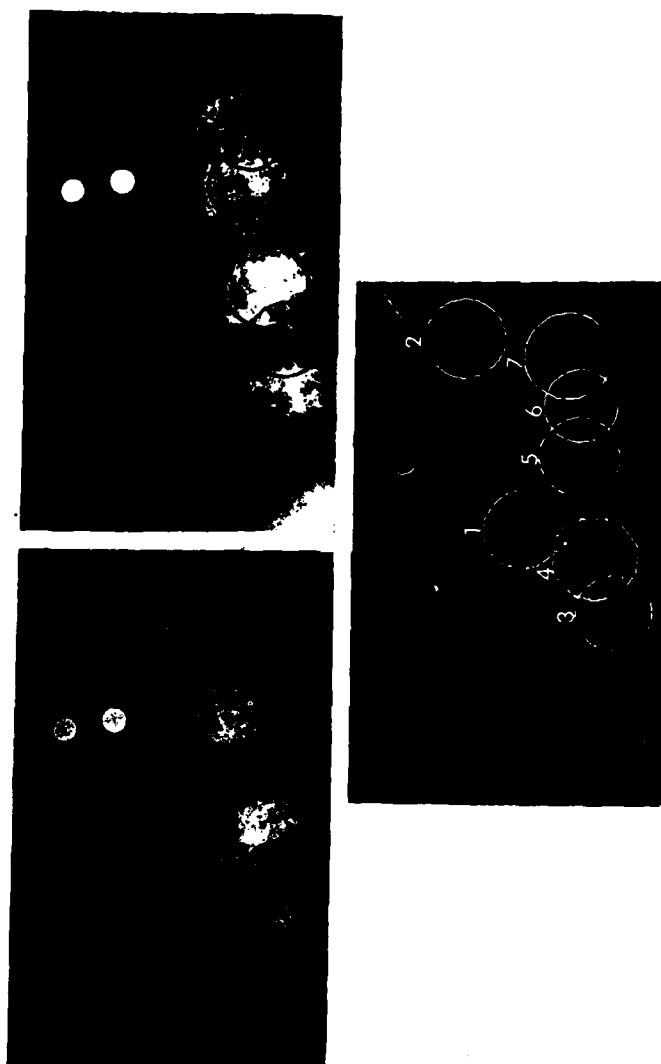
Representative example of corresponding pre- and post-operative radiographs and the ensuing subtraction image. *Upper left:* Pre-operative radiograph. *Upper right:* Post-operative radiograph. *Below:* The subtraction image.
